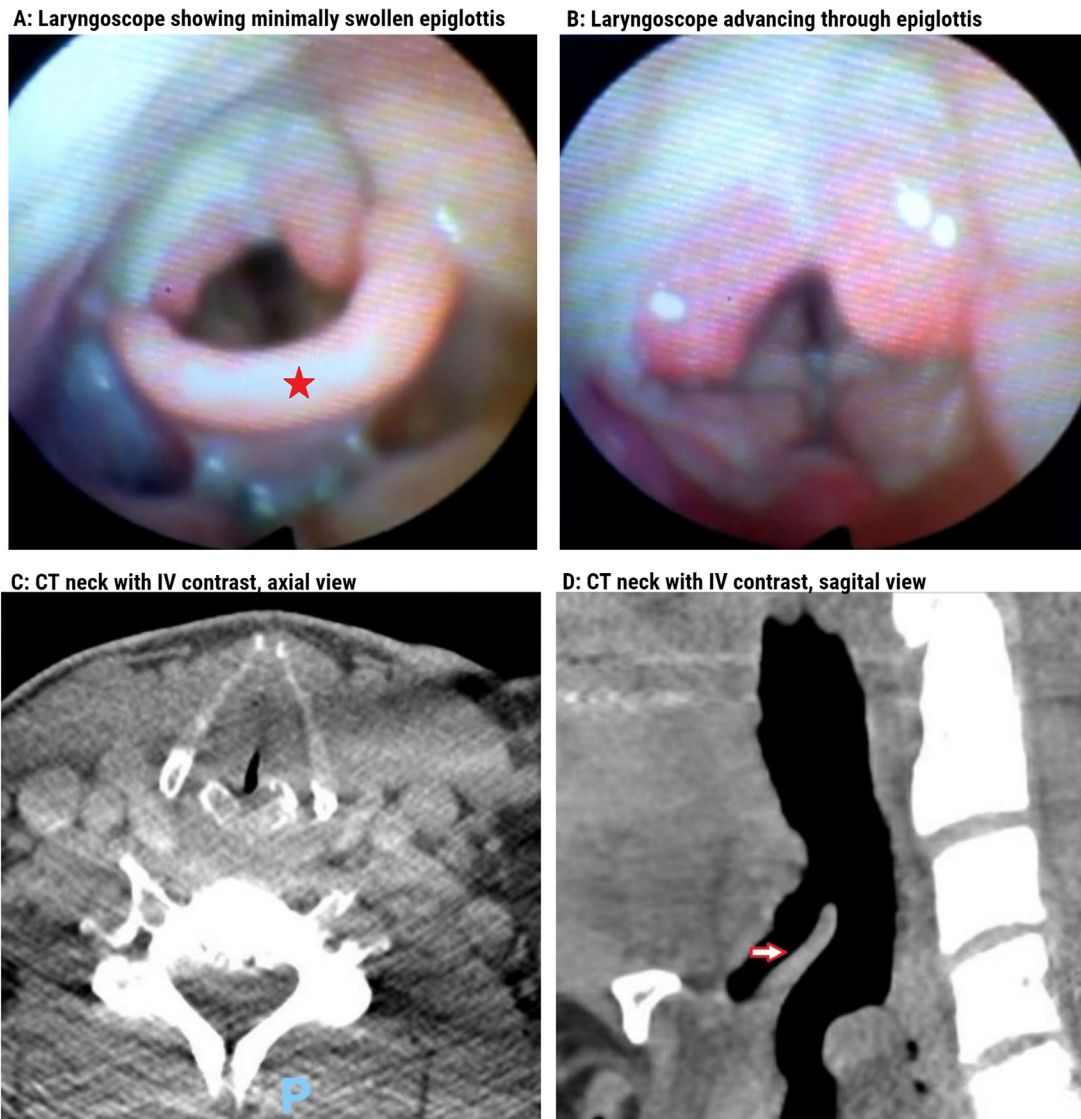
Supraglottitis due to COVID-19. A. Bedside flexible fiberoptic laryngoscope showed minimally swollen epiglottis (asterisk). B. Soft tissue swelling can be seen in the supraglottic areas after the laryngoscope advancing through epiglottis. C. Computed tomography (CT) neck axial view showed homogeneous low-density soft tissue thickening involving the aryepiglottic folds, false cords and glottis bilaterally and there was thickening of the anterior and posterior commissure with narrowing of the laryngeal airway. D. Sagittal view of the CT neck showed mild edema of the epiglottis (arrow).
